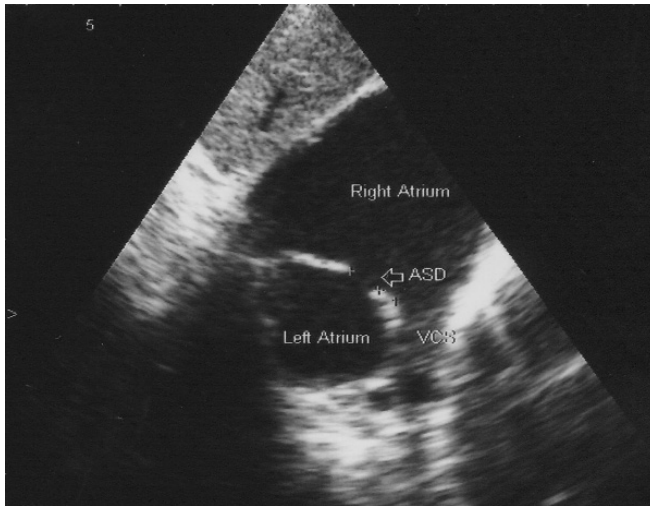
Postoperative echocardiography showing surgically created atrial septal defect. VCS indicates vena cava superior.
